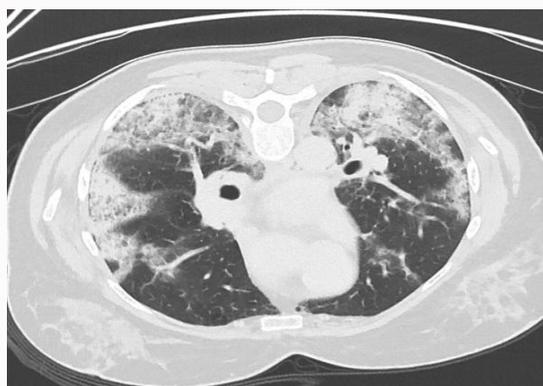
Axial view of high resolution computed tomography images of the chest showing bilateral, mainly peripheral ground glass opacities due to COVID-19 pneumonia.
